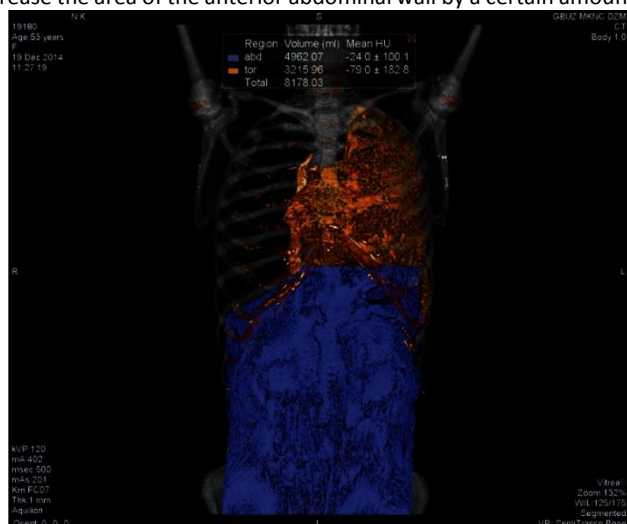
CT scan of the chest and abdominal cavities. Determination of abdominal organs volumes (blue color) and hernial contents (orange color)
